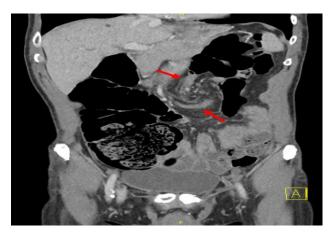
CT image demonstrating mesenteric swirl, with red arrows pointing to the two transition points of the transverse colon, generating a closed loop obstruction, or transverse colon volvulus.
